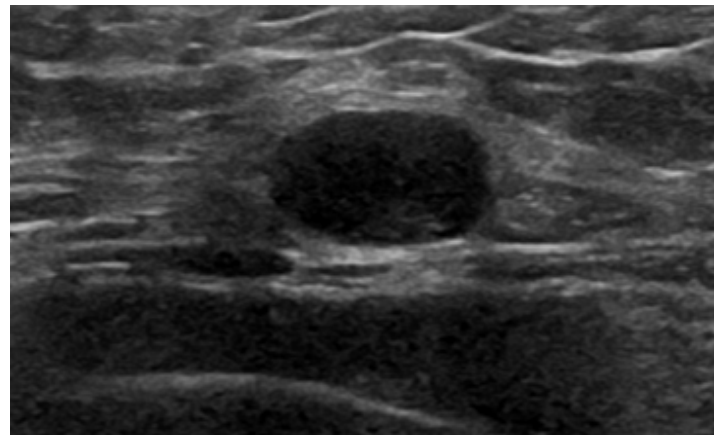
Targeted right breast ultrasound demonstrating a 1.3 x 0.7 cm well circumscribed hypoechoic homogenous mass at 5 o'clock of the right breast.
